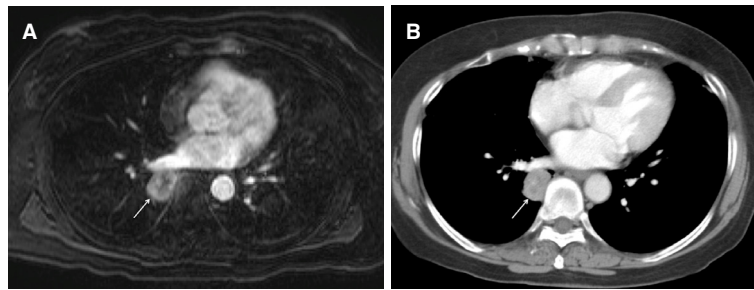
Magnetic resonance imaging and computed tomography (CT) showing a right lower lobe mass. The axial T1-weighted fat-suppressed postcontrast (A) and enhanced CT (B) images show an enhancing mass in the right lower lobe (arrow)
